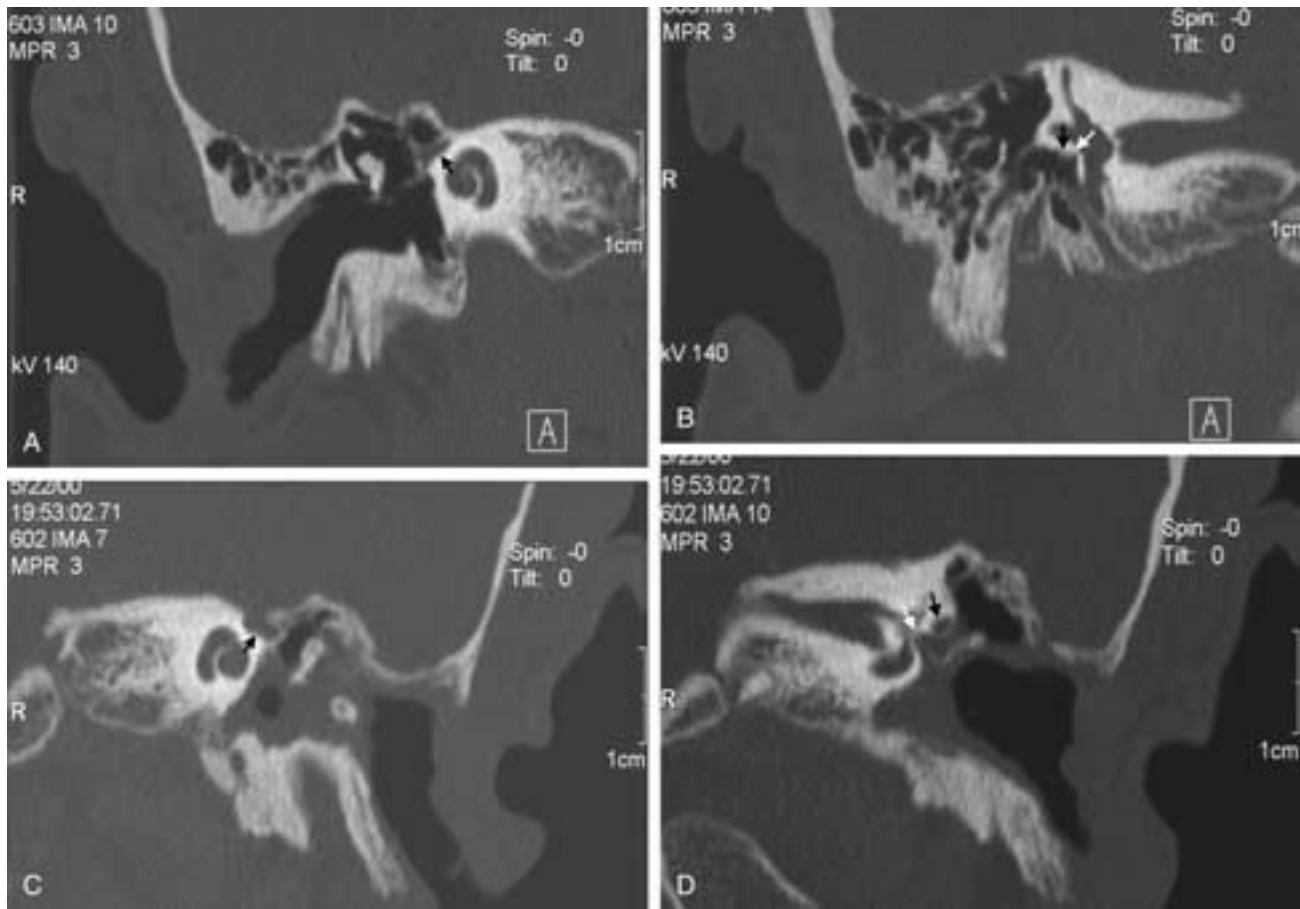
Moebius syndrome (congenital facial diplegia). A and B, Two coronal CT images from anterior to posterior showing a small right geniculate ganglion (black arrow in A) and a small tympanic segment of the right facial nerve (black arrow in B). Also note the stenotic oval window (white arrow in B). C and D, One mm coronal CT images from anterior to posterior showing a normal left geniculate ganglion (black arrow in C) and a normal tympanic segment of the left facial nerve (black arrow in D) and a normal left oval window (white arrow in D). The soft tissue in the left EAC is postoperative.
